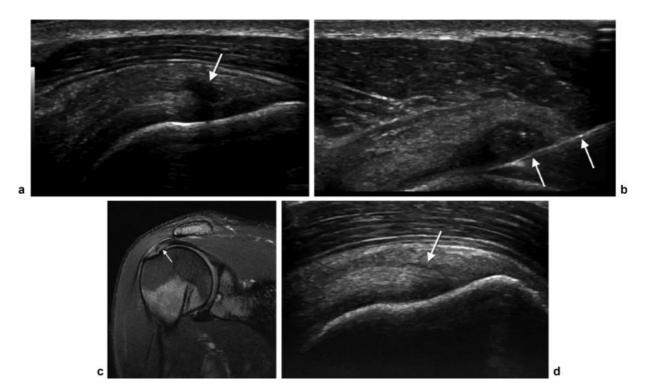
(a) A 37-year-old woman with shoulder pain. Longitudinal sonogram of the supraspinatus shows focal area of intrasubstance hypoechogenicity suggestive of an interstitial tear (arrow). (b) A 37-year-old woman with shoulder pain. Longitudinal sonogram of the supraspinatus shows a 22G needle (arrows) placed within the focal area of intrasubstance hypoechogenicity during platelet-rich plasma (PRP) treatment. (c) A 37-year-old woman with shoulder pain. Coronal T2-weighted fat-saturated magnetic resonance imaging of the shoulder demonstrates small area of intrasubstance high signal (arrow) corresponding to the ultrasound abnormality seen. (d) A 37-year-old woman 4 months after PRP treatment. Longitudinal sonogram of the supraspinatus shows near-complete resolution of the focal area of intrasubstance hypoechogenicity (arrow) suggestive of healing. Patient's pain and function improved.
